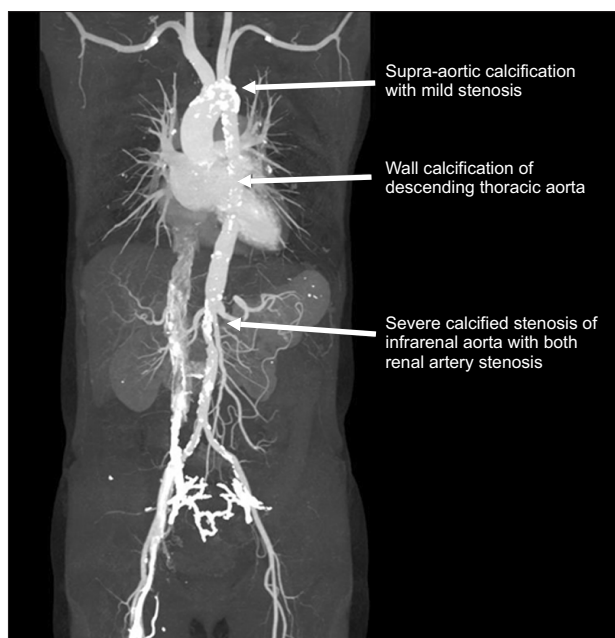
Preoperative computed tomography angiography showed multiple calcification and stenosis in the aorta.
